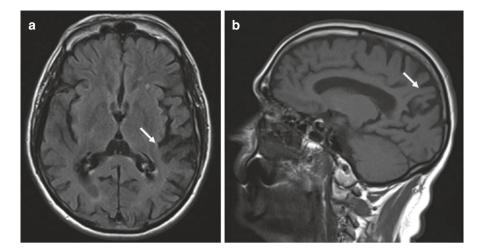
(a) T2 FLAIR axial image and (b) T1 sagittal image showing prominent parietal atrophy (*arrows*)
